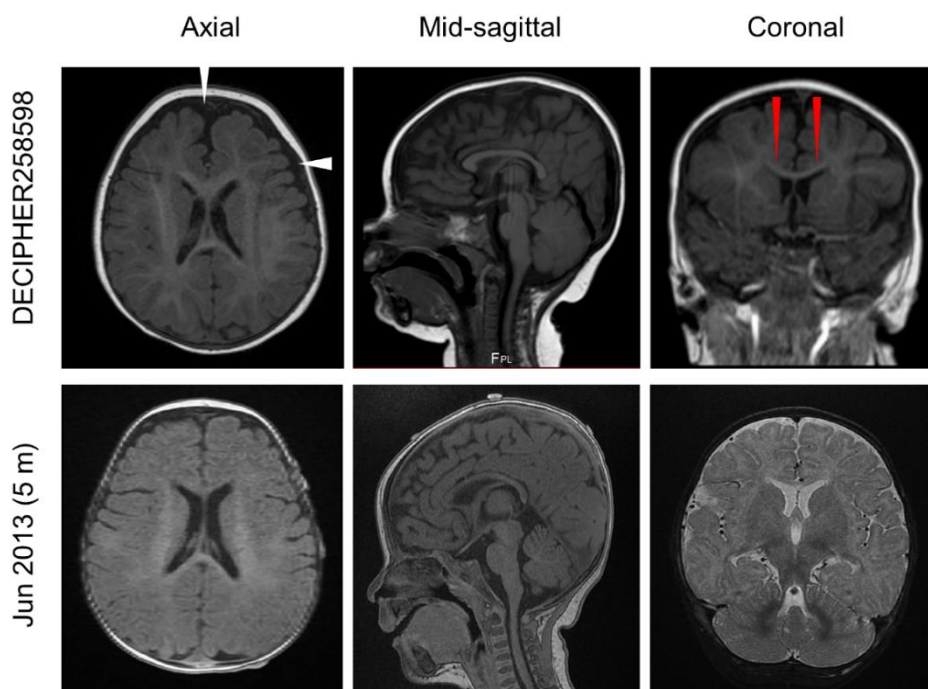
Brain MRI images of patients with triploid (top) vs diploid (bottom) *TP53BP2* in the germline. MRI of DECIPHER258598 taken at 11 months and Jun et al at 5 months of age as a normal control. White arrowheads – prominent subarachnoid space; red arrowheads – effacement of superolateral aspects of ventricular lumens.
